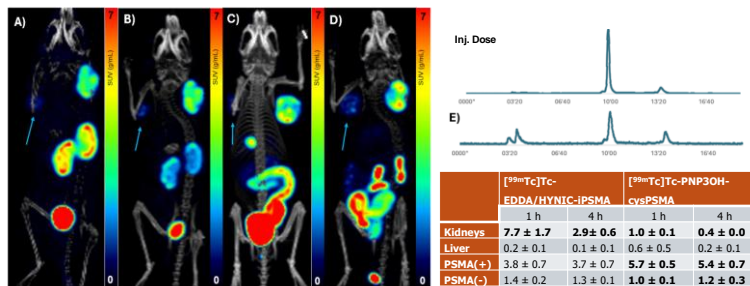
Fused $\mu\text{SPECT}/\text{CT}$ images of $[^{99m}\text{Tc}]\text{Tc-EDDA/HYNIC-iPSMA}$ at 1 h (A) and 4 h (B) p.i. and of $[^{99m}\text{Tc}]\text{Tc-PNP3OH-cysPSMA}$ at 1 h (C) and 4 h (D) p.i. The arrows indicate the location of the PSMA-negative tumors. Representative radio-chromatogram of urine sample (E) taken at 1 h p.i. Table summarized the quantitative SUVmax data obtained from $\mu\text{SPECT}/\text{CT}$ images (N=3 per time-point).
